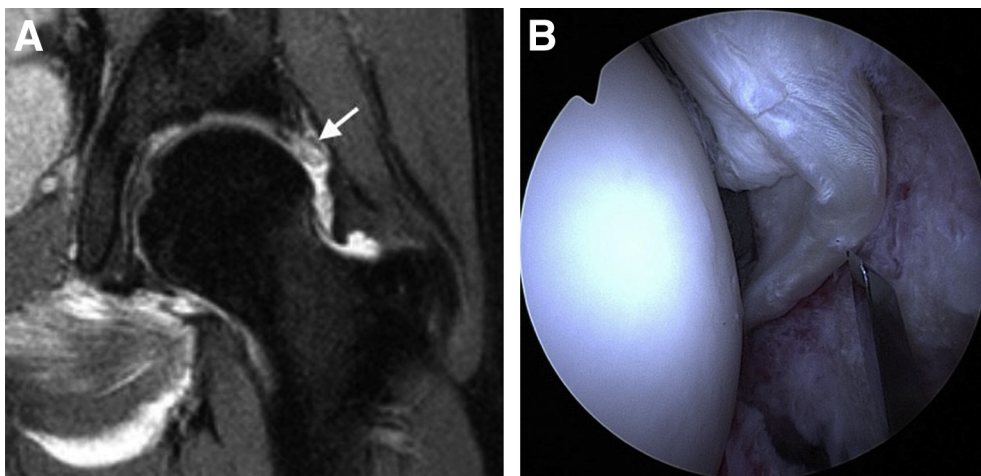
(A) Magnetic resonance images showing large labral tear (arrow) on coronal view. The labral tissue is distorted and degenerative anterosuperiorly. (B) Arthroscopic view from the modified anterior portal shows the torn and degenerated labrum.
